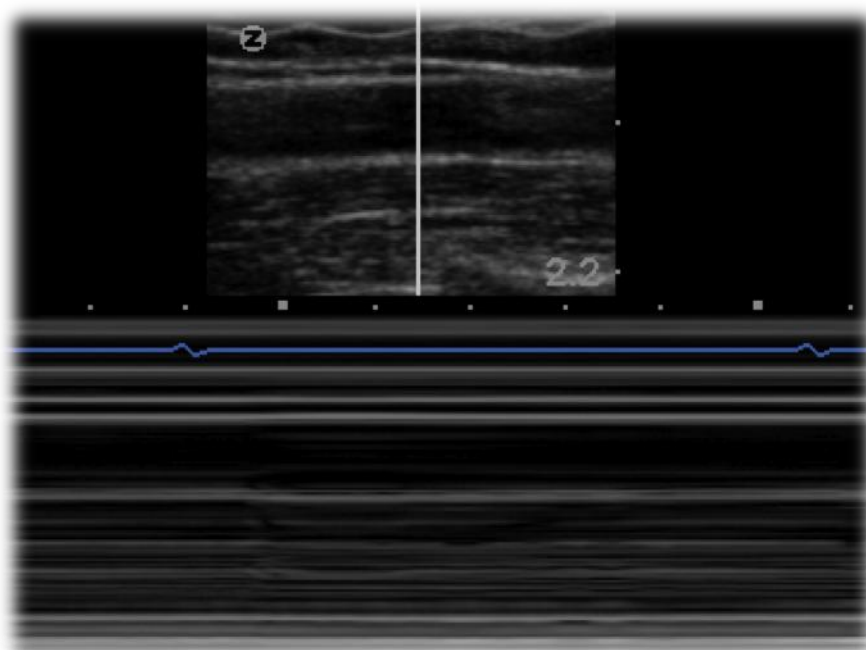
M mode ultrasound image of the brachial artery
